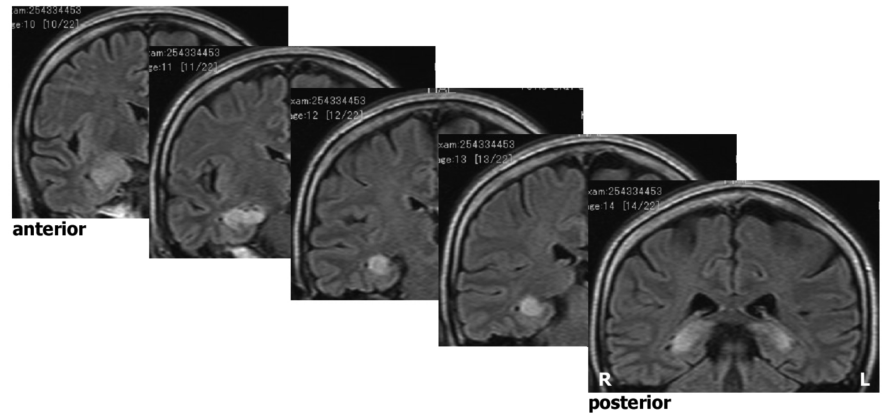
Brain magnetic resonance imaging of the patient. Bilateral, symmetrical high signal lesions localized in the body to the infundibulum of the hippocampus, which slightly extended to the parahippocampal gyrus and the amygdala on fluid attenuated inversion recovery (FLAIR) images. Coronal images are shown. Pre-existing mild malformation in the temporal neocortex was also noted.
